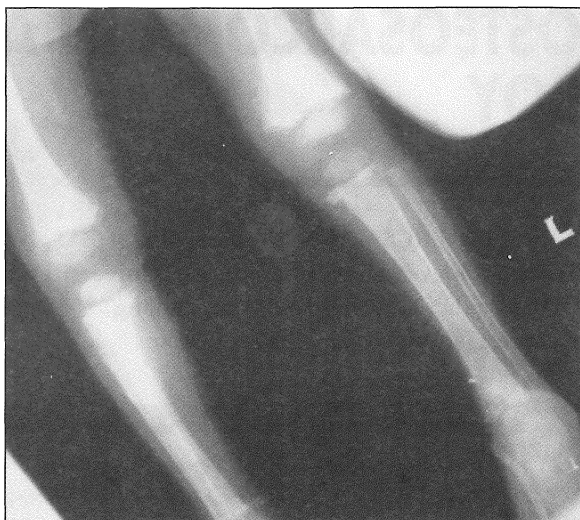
Plain X-ray showing multiple secondaries in both femurs and tibiae.
